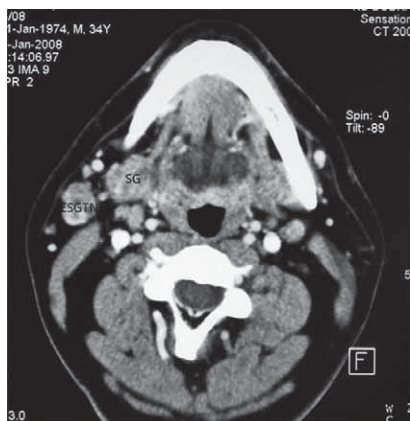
CT scan showing ectopic salivary gland tissue neoplasm posterior and separated from the submandibular gland. ESGTN – ectopic salivary gland tissue neoplasm, SG – submandibular gland.
